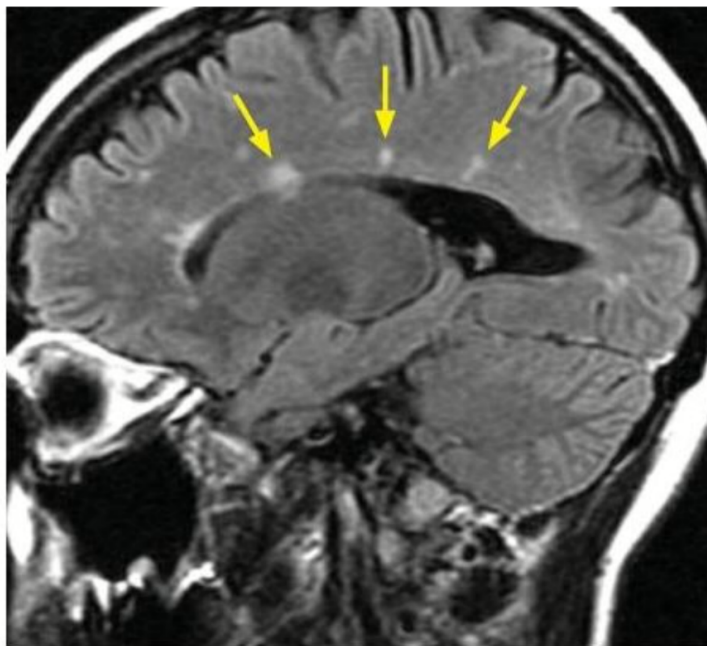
Hyperintense periventricular lesions (also known as Dawson fingers) on a sagittal fluid attenuated inversion recovery (FLAIR) image (Mandell, 2013).*
